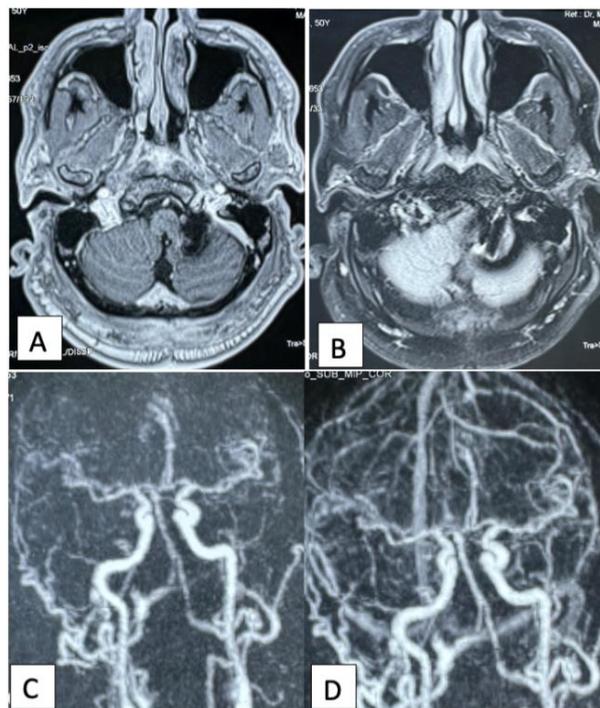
Brain MRI, axial T2 flair (A), T2* (B): artefact around the vascular clip, Cerebral angiography with MIP reconstruction in frontal section (C): complete DAVFs, absence of any vascular lesion.
